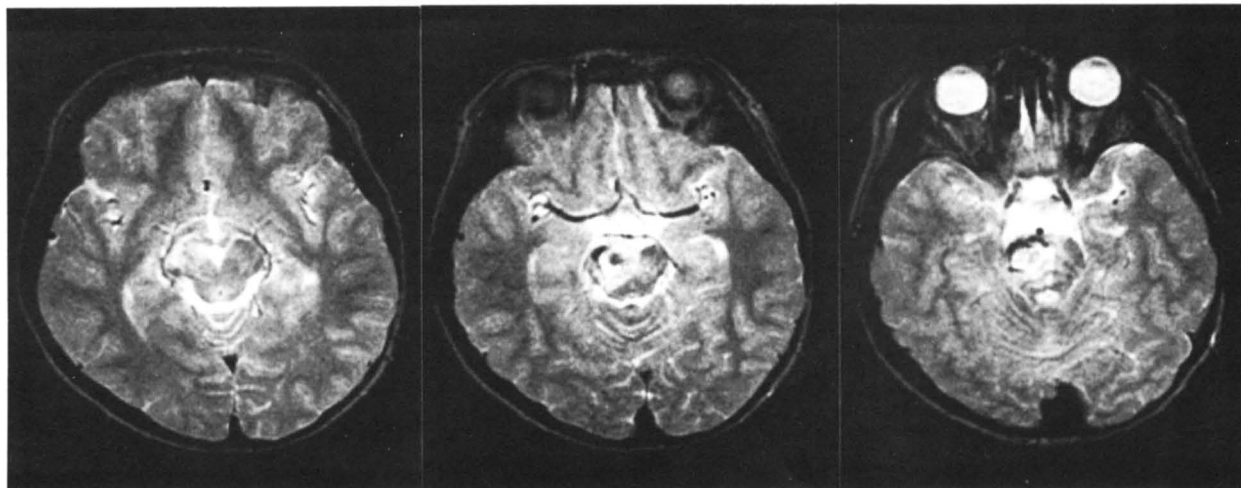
Findings of magnetic resonance imaging on 6 February 1992. T₂-weighted images (1.5 T, spin echo; T_R/T_F: 3,000/90).
